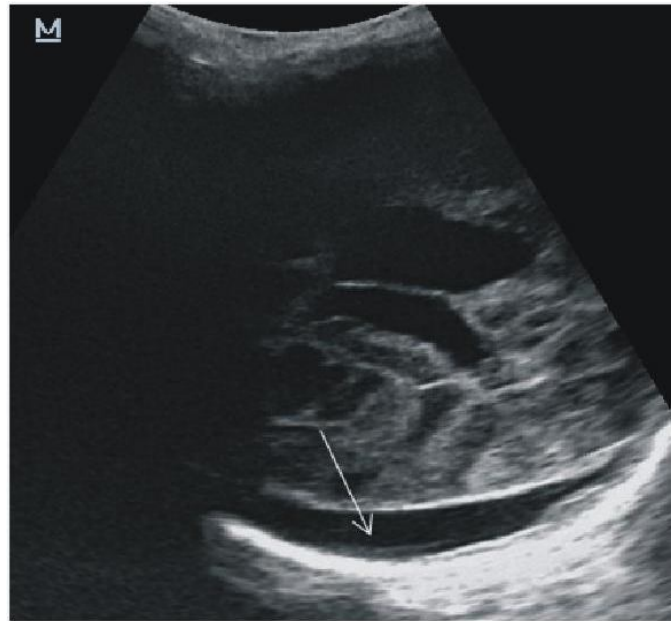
Neurosonogram Coronal Image Shows Changes of Encephalomalacia (Arrow) Secondary to Chronic Ischemia - 4 Week Scan
